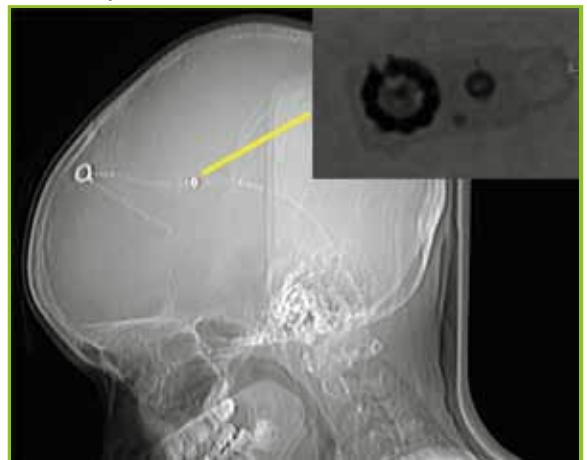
X-ray showing a programmable ventriculo-peritoneal shunt and a magnified view of the programmable component.
